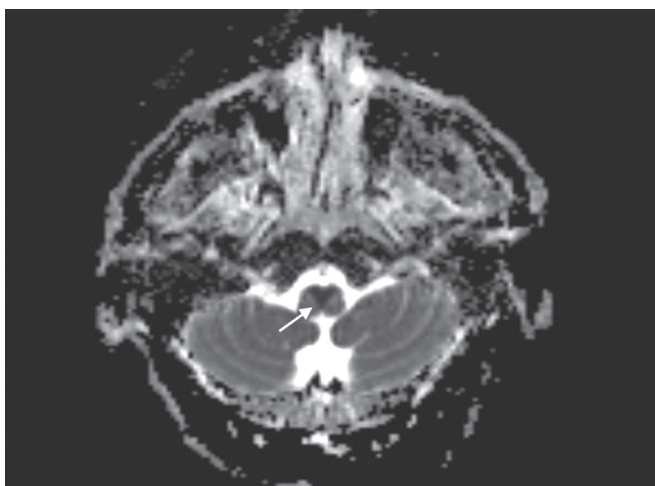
Magnetic resonance imaging brain axial apparent diffusion coefficient image showing heart-shaped hypointensity in the ventral medulla
